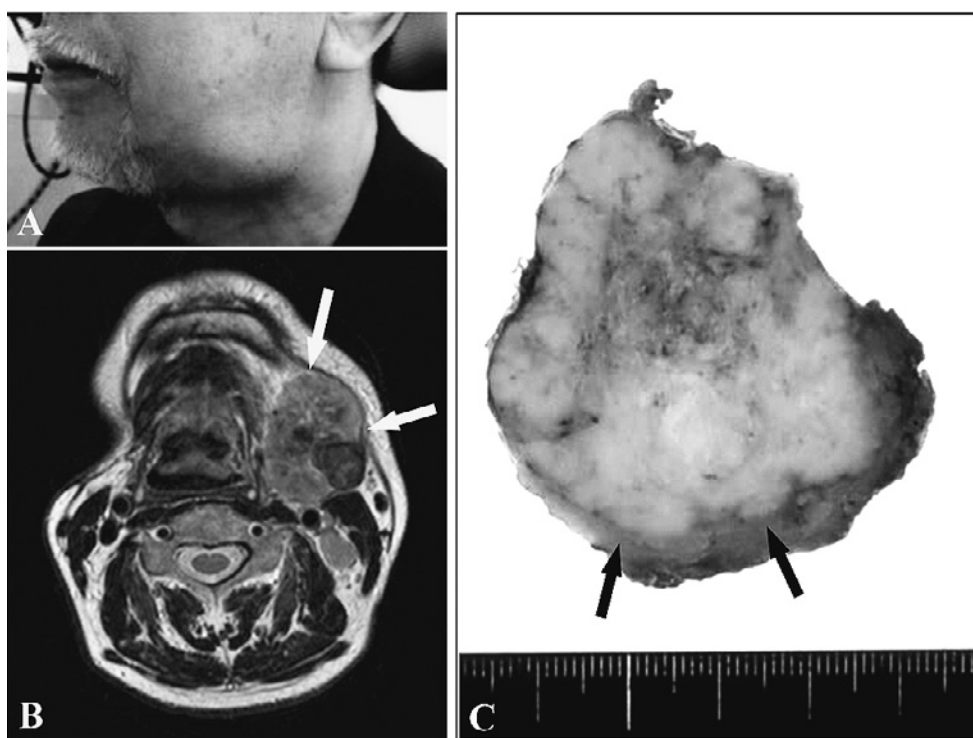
The patient presented with a bulging mass in his left submandibular gland region (A). Magnetic resonance imaging (T2) revealed an irregularly shaped heterogenous lesion measuring up to 4.5 cm involving the left submandibular gland (B, arrows). On gross examination, a solid-white nodule was noted with central bleeding and necrosis, invading into the adjacent adipose tissue (C, arrows).
